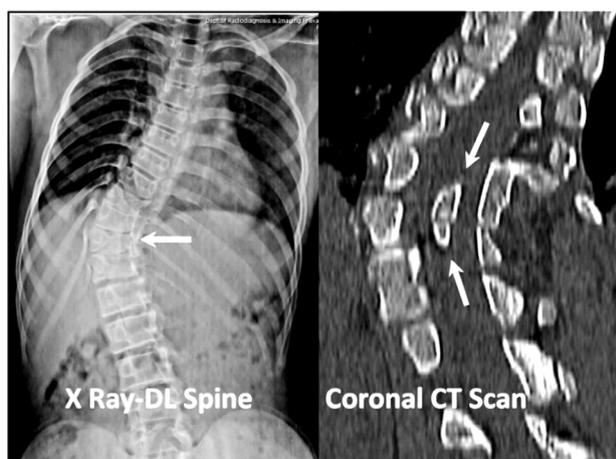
X-ray Spine and Coronal CT image showing calcified bar splitting the spinal canal and a scoliosis having concavity towards left.
